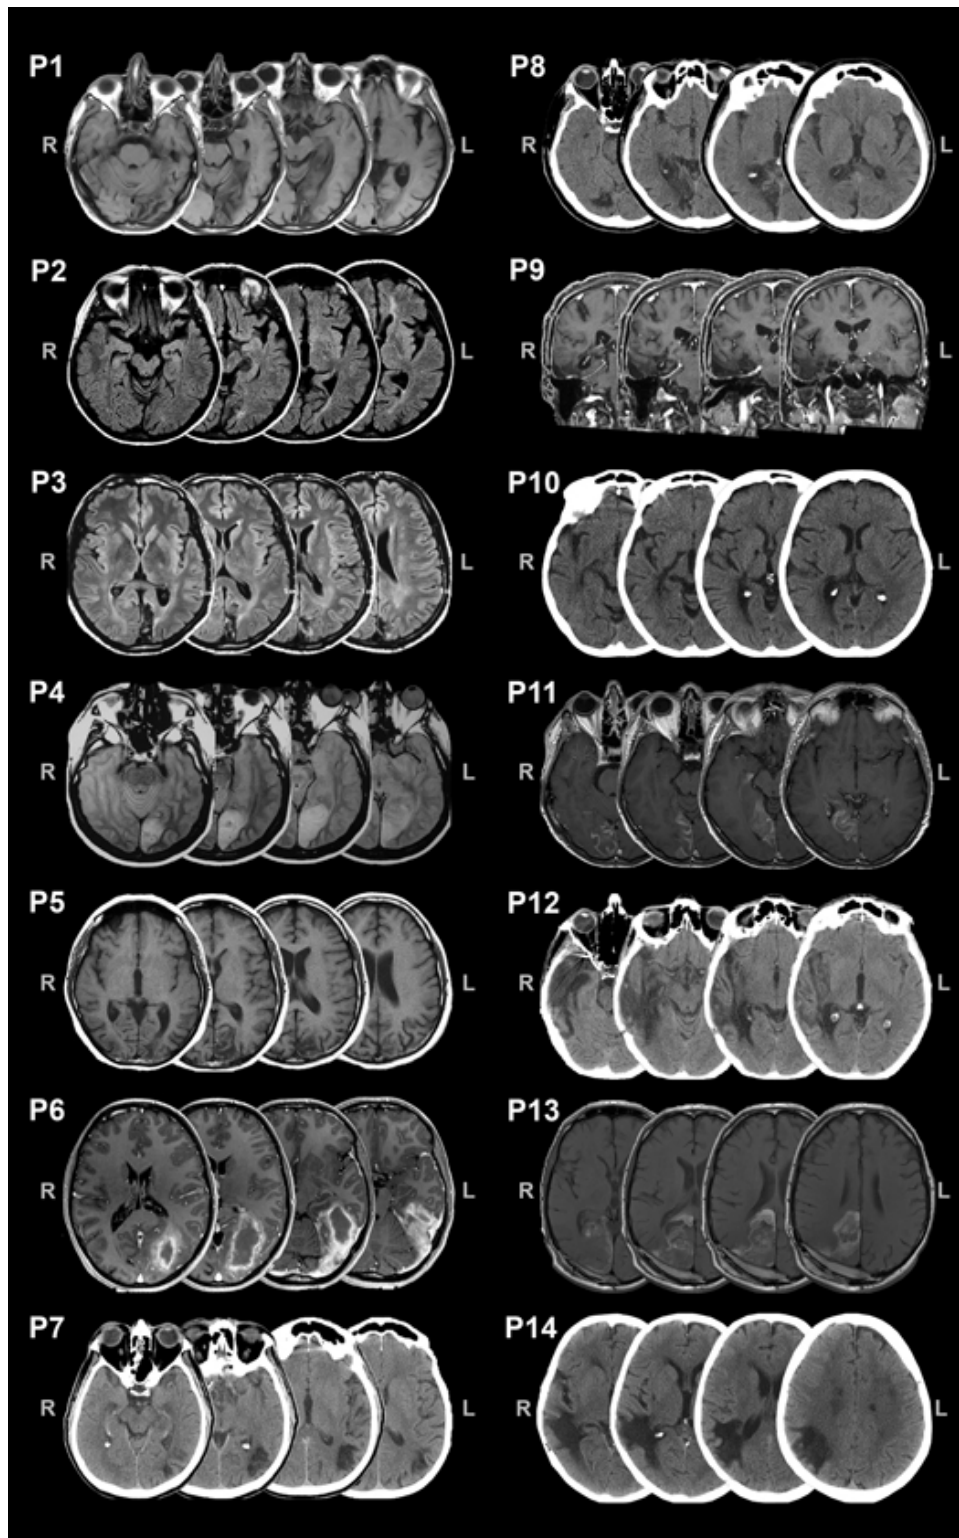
CT or MRI scans of patients. All the scans are presented in axial views except for those of P9, which are presented in coronal views. R: right; L: left.
